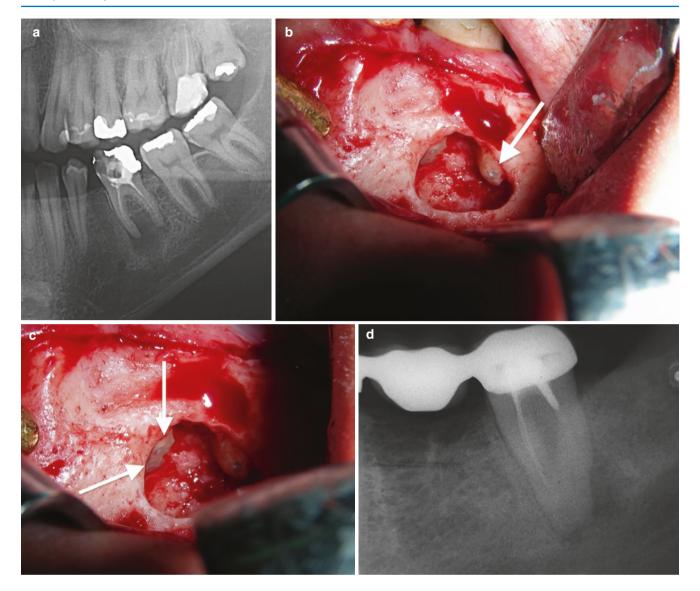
The lower molar apicoectomy. (a) Preoperative radiography showing a large periapical lesion involving the tooth 46 as a result of inadequate root canal treatment. (b) The three-sided submarginal MPF is reflected; periapical granulation tissue curetted and apicoectomy is performed with retrograde root canal filling (arrow points to the distal root foramen that is sealed). (c) The same operative site, photograph taken at different angle showing retrograde filling of the mesial root foramina (arrow). (d) Preoperative radiography showing the tooth 47 with periapical lesion. (e) Close-up view of the operative site showing retrograde filling of two mesial foramina and one distal foramen. (f) Wound closure 10 days following surgery. (g) Preoperative radiography showing teeth with inadequate root canal treatment. Fistula is formed in the vestibule of the lower first molar (arrow). (h) Operative site following curettage and apicoectomy. The dental screw post is gradually retrieved from the distal root canal. (i) All four root foramina are sealed using MTA (arrows). (j) A limited size periosteal inverted flap is raised to provide a dual layer closure over the mesial root that is only partially covered with bone. The arrow points to the proliferation tissue at the entrance of the fistula. (k) Wound closure. The fistula is lightly curetted; the superficial layer cut off and left to heal by secondary intention. (I) Clinical photograph taken at surgery showing the first and the second lower molars with marginal bone defects. (m) Apicoectomy with retrograde root canal filling is performed and marginal bone defects curetted. (n) Bony defects are filled with DBBM granules. (o) Wound closure. (p) Postoperative photograph taken 1 year following the procedure showing good soft tissue healing.
